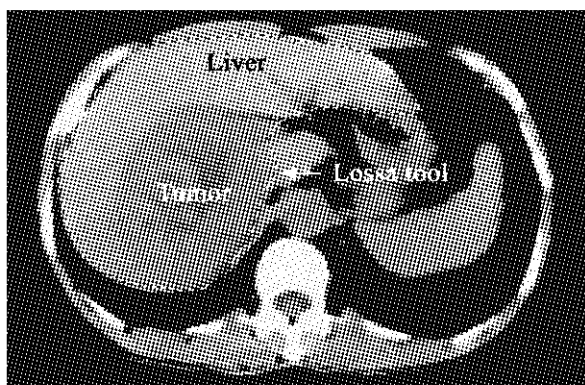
The JPEG image file of CT film is opened by PhotoShop. The edges of the liver were accurately margined by the lossa tool.
